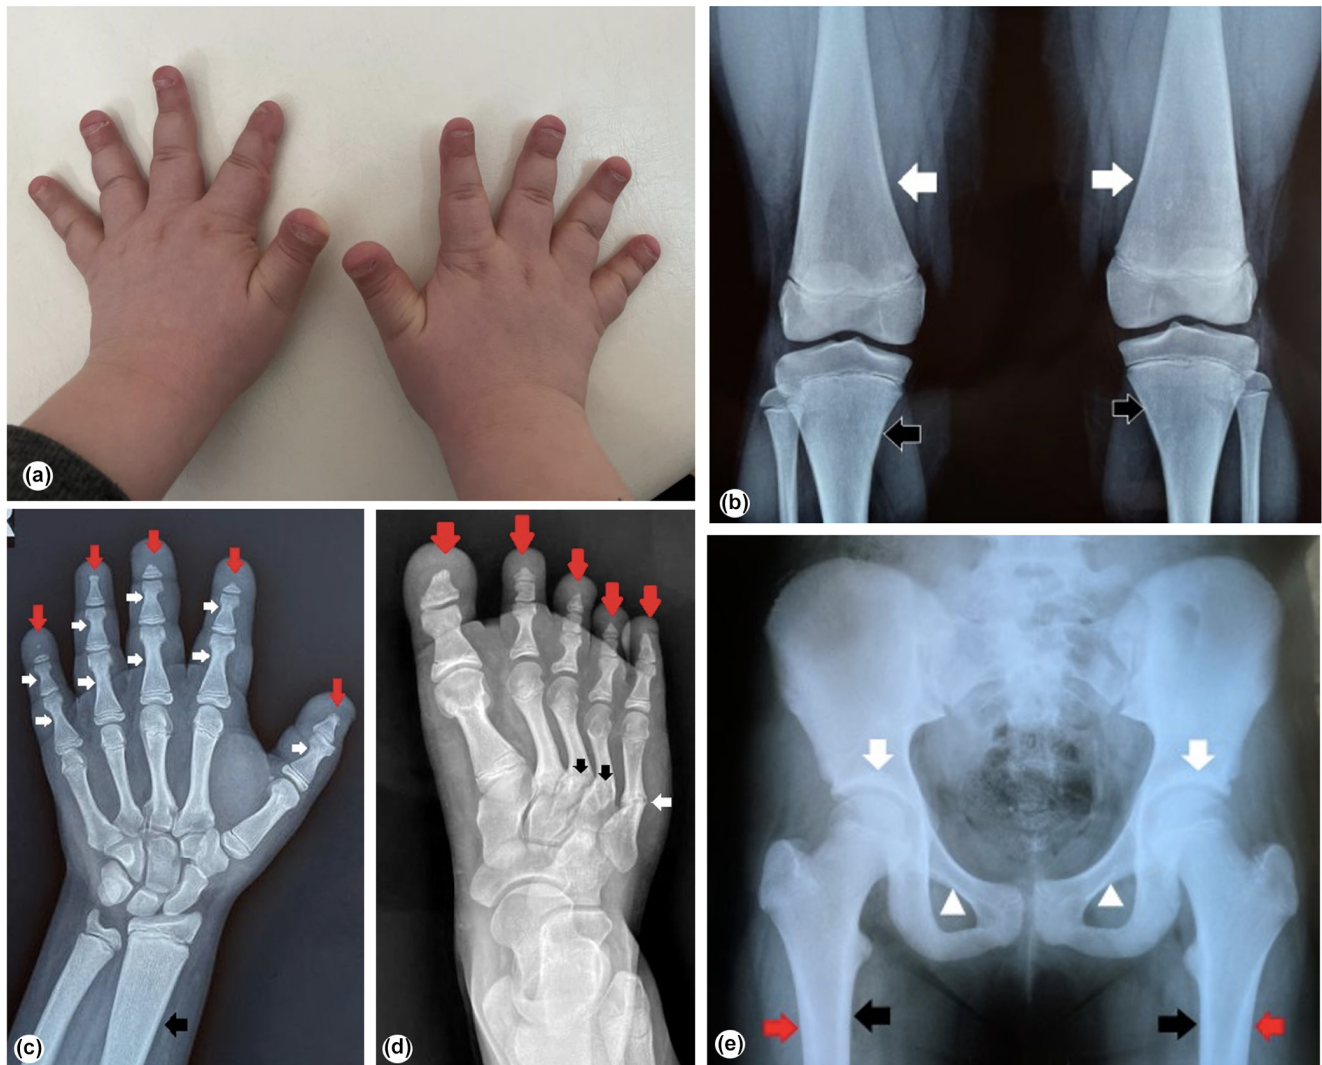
Clinical and radiological features of second patient. (a) Outer appearance of the hands. (b) AP radiographs of the both knee joints: Undertubulation of the distal metaphyses of the femora (white arrows) and proximal tibiae (black arrows). (c) AP radiograph of the hand: Osteolysis of the distal ends of the distal phalanges (red arrows); narrowing of the diaphyses of the middle and basal phalanges (white arrows); undertubulation of the distal metaphysis of the radius (black arrow). (d) AP radiograph of the foot: Osteolysis of the distal ends of the distal phalanges of the toes (red arrows); healing fracture of the fifth metatarsal (white arrow); healed fractures of fourth and third metatarsals (black arrows). (e) AP radiograph of the pelvis and hips demonstrates normal hip joints, increased bone density in the supraacetabular areas (white arrows), thickening of the cortical layers of pubic bones (white arrowheads), thickening of the inner (black arrows), and outer (red arrows) cortical bone of the proximal femur
